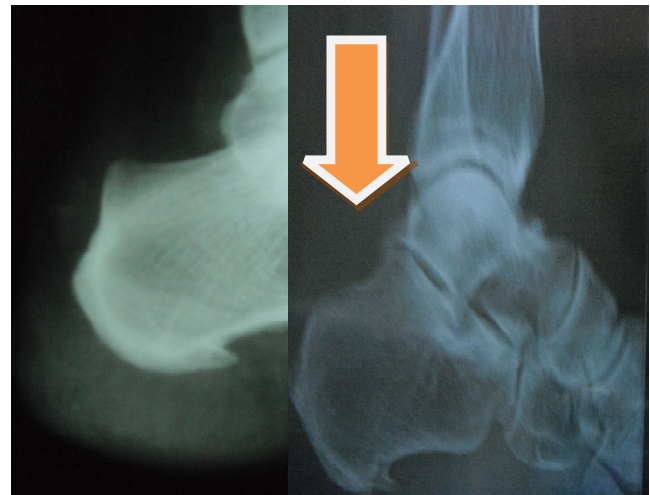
(left) Pre-operative x-ray showing Haglund bump and figure 6 (right) showing Post-op x-ray with removed bony bump shown by arrow head
